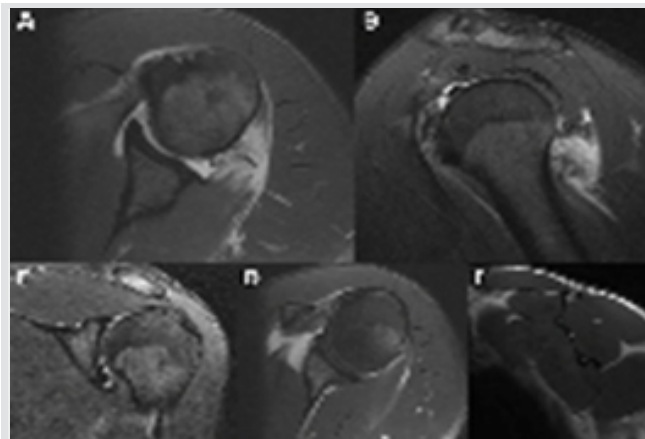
Magnetic resonance imaging showing an isolated teres minor (TM) myotendinous lesion. (a) Axial view, T2 (distal): Myotendinous tear of TM, (b) Sagittal view, T2: Isolated tear of TM. (c) Coronal view T2: No lesion of the supraspinatus. (d) Axial view, T2 (proximal): No lesion of infraspinatus or subscapularis. (e) Sagittal view, T1 (Y view): No atrophy of the muscles, no fatty infiltration.
